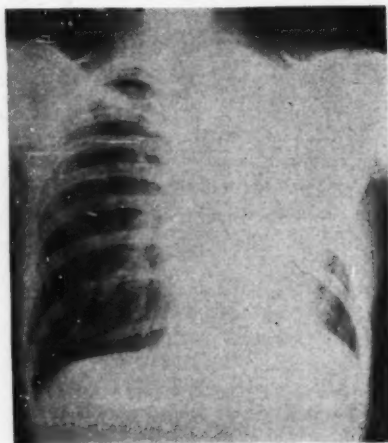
The same patient three months later. Radiography now reveals a complete bronchial obstruction with atelectasis. Patient expired two months later. Post-mortem examination revealed an extensive bronchogenic carcinomatous involvement of the left lung with superimposed pulmonary suppuration.
